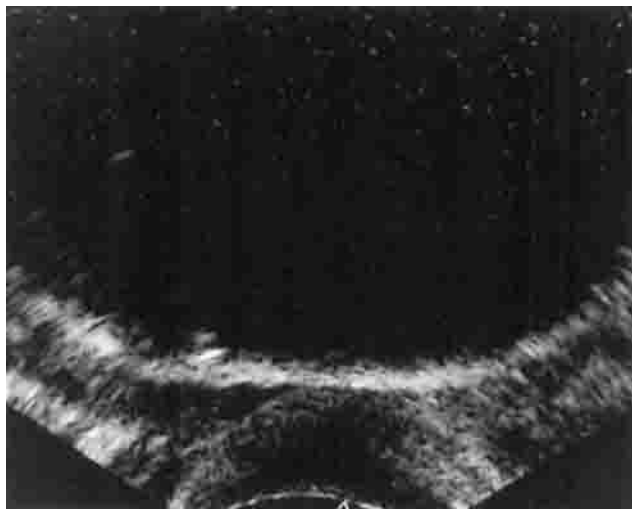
Ice ball formation as visualized by transrectal ultrasound (transverse view).
